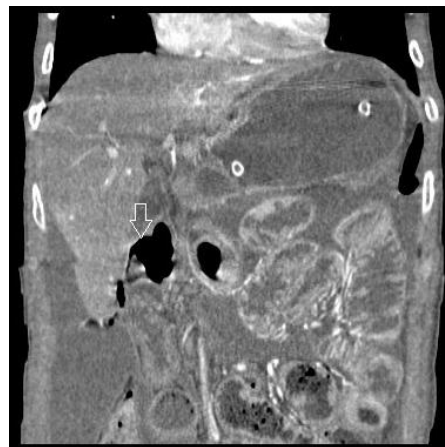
Coronal CT abdomen arterial phase shows a rent is in the first part of the duodenum (arrow) with intraperitoneal free air in right subhepatic region. Free fluid is present in the peritoneal cavity.
